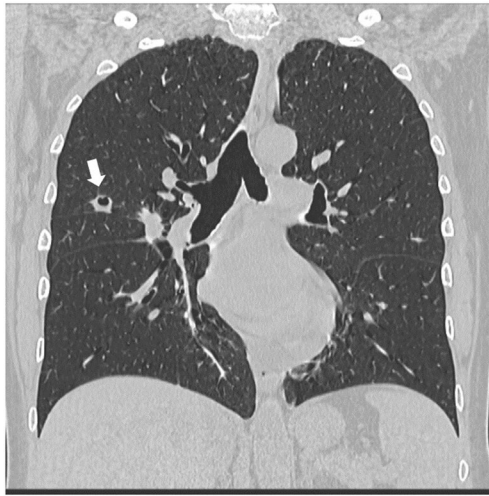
Coronal chest CT scans showing two nodular lesions with spiculated margins in the posterior segment of the right upper lobe. One lesion is cavitated (white arrow)
